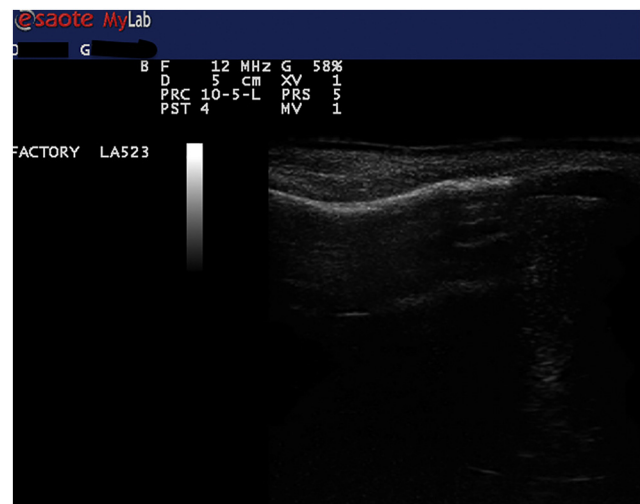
Ultrasonography images of normal nasal bone.
